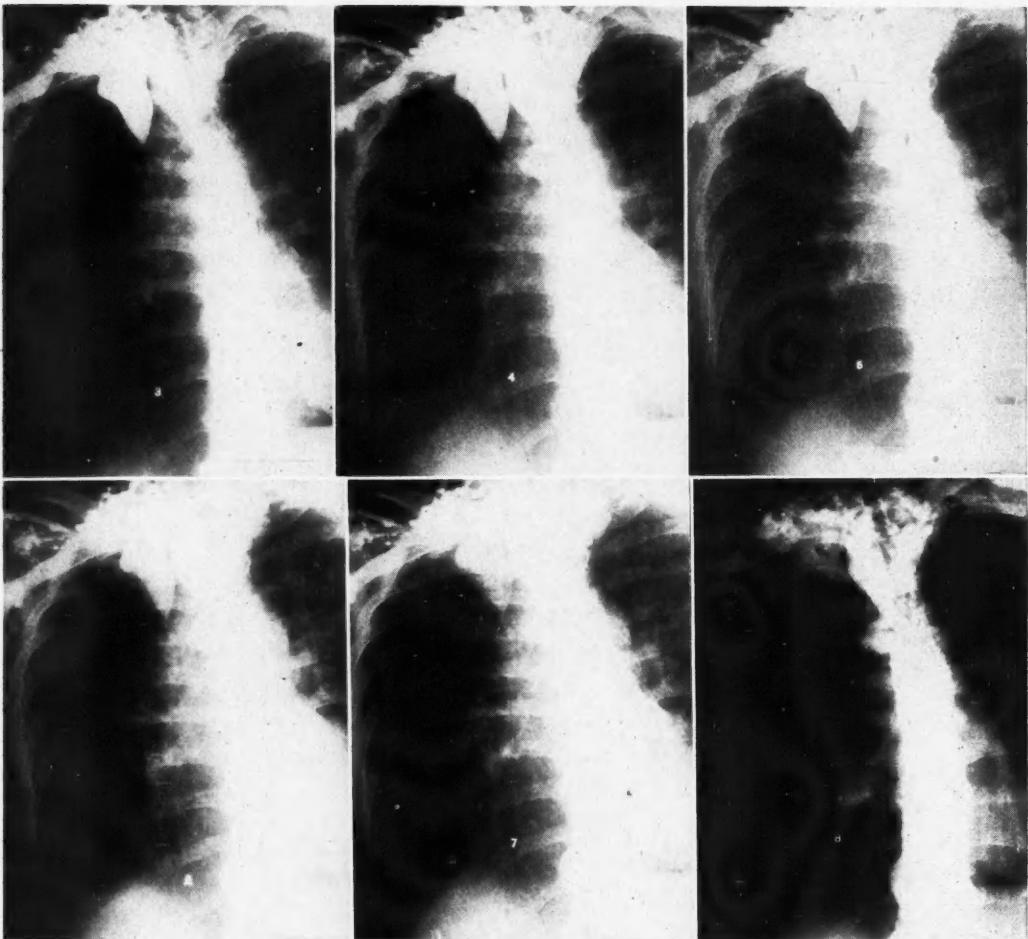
Serial roentgenograms (time interval between roentgenograms 4/5 second) on a 50-year-old woman. Forty cc. of 70 per cent Diodrast was injected into the left cubital vein. The progress of the opacified blood can be followed as it visualizes the occluded superior vena cava and the collateral circulation.
